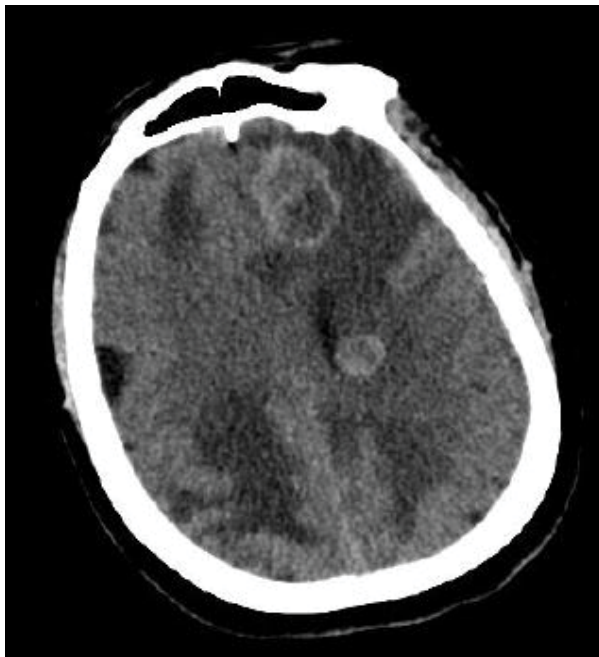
Multiple brain metastasis in CT (Metastasis after 11 months).
